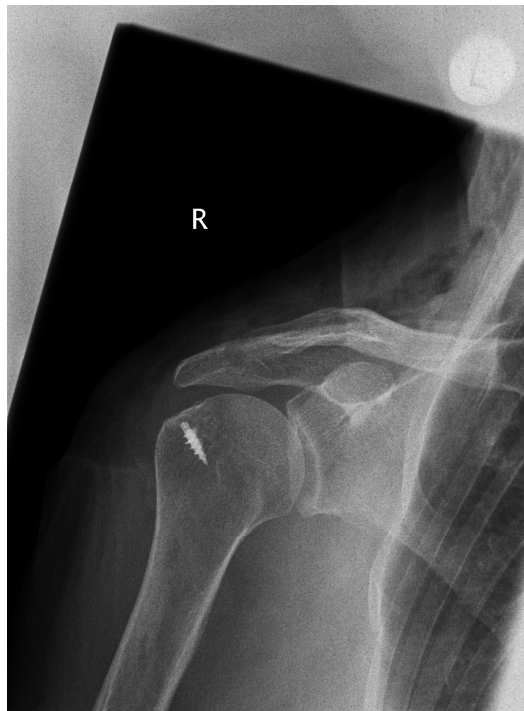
Postoperative X-ray following the repair of the full thickness tear
